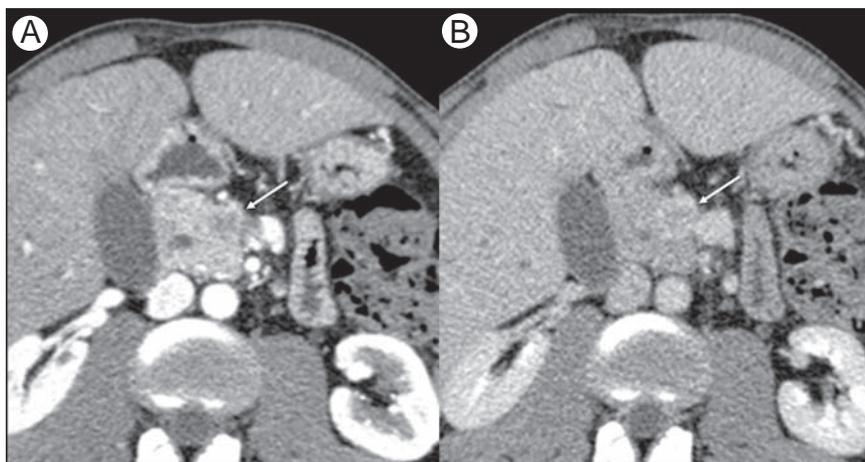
Eosinophilic pancreatitis in a 36-year-old man with a previous diagnosis of eosinophilic pneumonia, presenting with abdominal pain and jaundice; the patient was referred to an abdominal CT scan after an US revealed dilatation of the biliary tree. Arterial (A) and portal (B) phases of contrast-enhanced CT demonstrate a small hypovascular nodule with progressive enhancement in the head of the pancreas (arrows). CA 19-9 was slightly raised (40,4 U/ml; normal < 37 U/ml). Endoscopic US-guided fine-needle aspiration confirmed eosinophilic pancreatitis.
